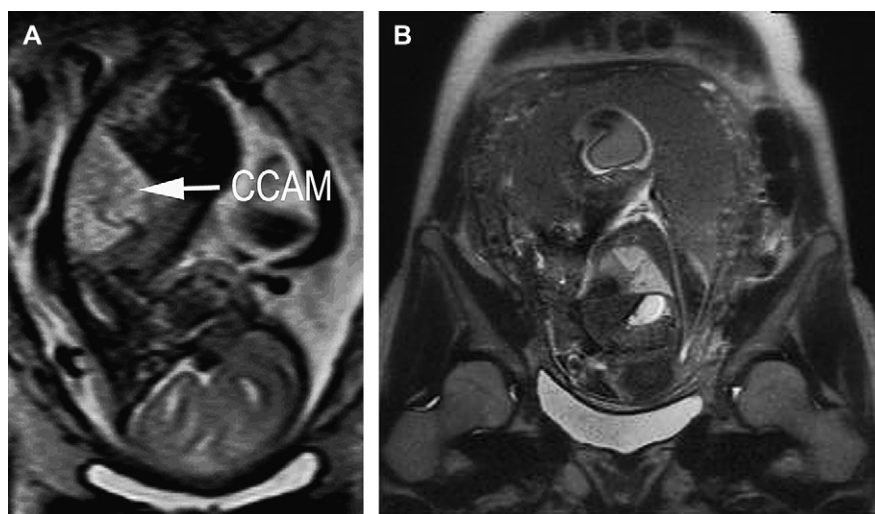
Magnetic resonance imaging (MRI) of (A) a microcystic congenital cystic adenomatoid malformation (CCAM), and (B) a macrocystic CCAM.
